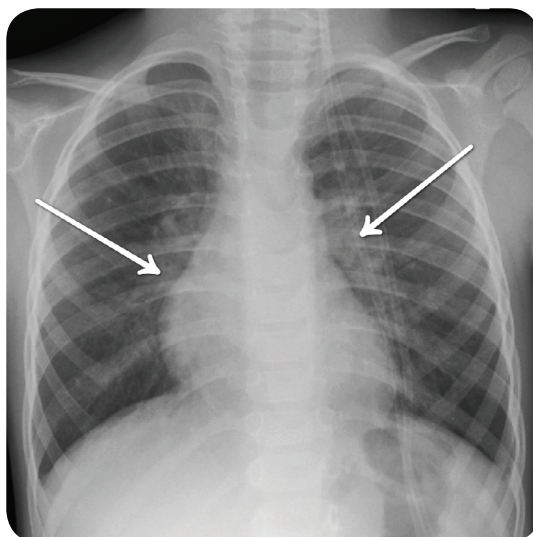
A plain chest radiograph in a child with bronchiolitis demonstrating bilateral hilar fullness.
